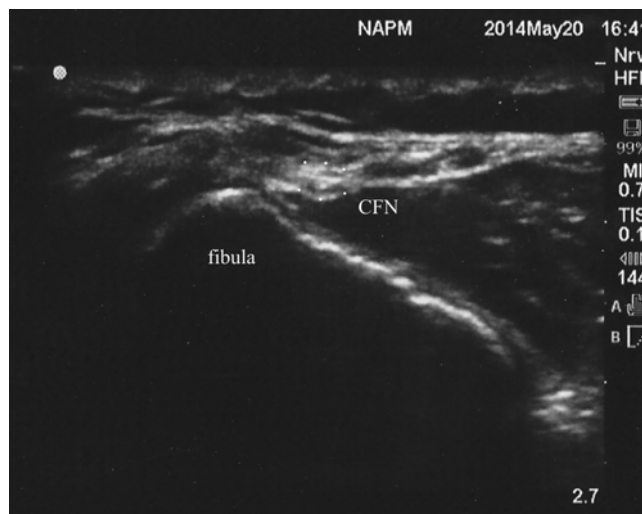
Ultrasound image of the common fibular (peroneal) nerve at the fibular head. *CPN* common peroneal nerve (Image courtesy Heath McAnally, MD)
